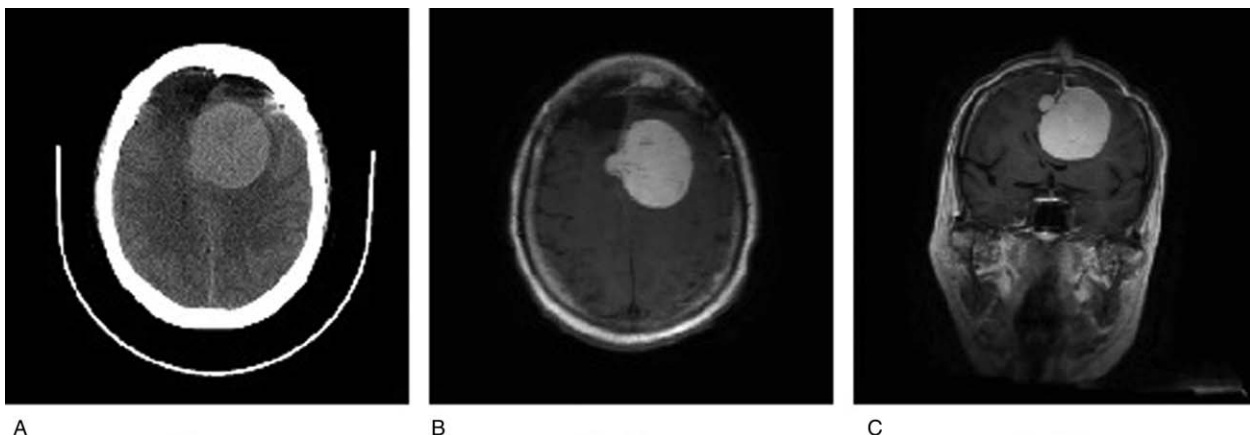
Pre-operative non-contrast computed tomography (CT) of the patient, axial view. (A) Pre-operative cranial magnetic resonance imaging, T₁-weighted gadolinium contrast. Axial (B) and coronal (C) views of the bilateral frontal lesions.
